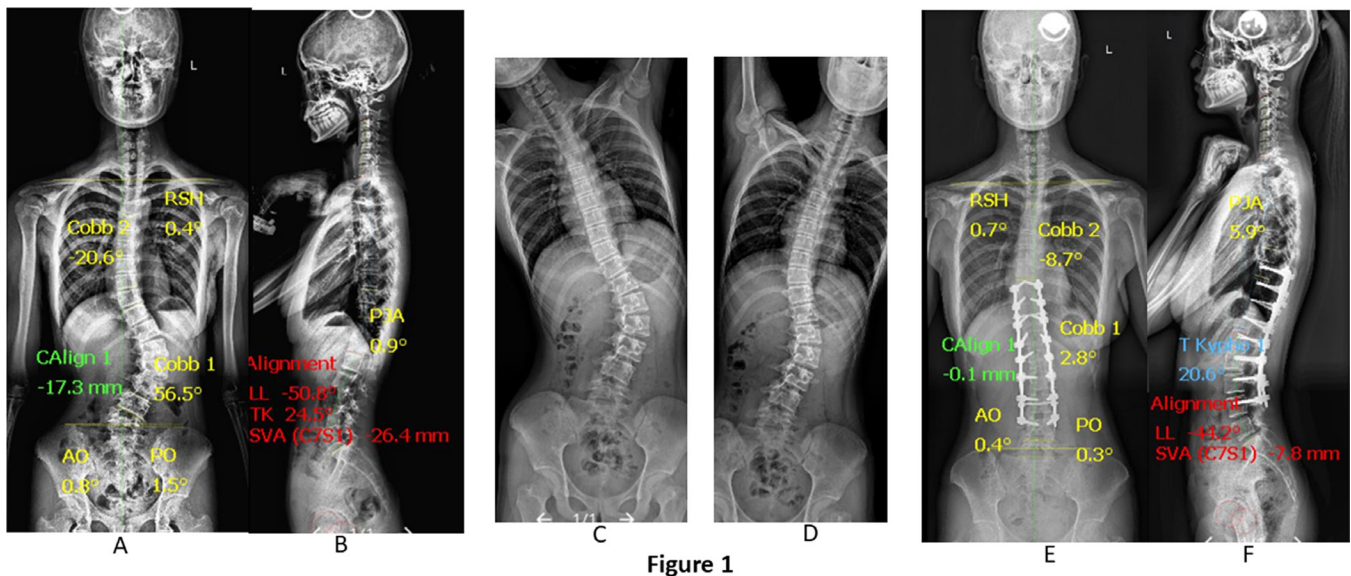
A 15-year-old girl with adolescent idiopathic scoliosis Lenke 5 curve. (A and B) Preoperative posteroanterior and lateral standing radiograph. (C and D) Preoperative bending radiography. (E and F) Three-year postoperative posteroanterior and lateral radiograph. The patient was treated with posterior en-bloc direct vertebral rotation (DVR) with upper instrumented vertebra (UIV) = upper-end vertebra (UEV) + 1.
